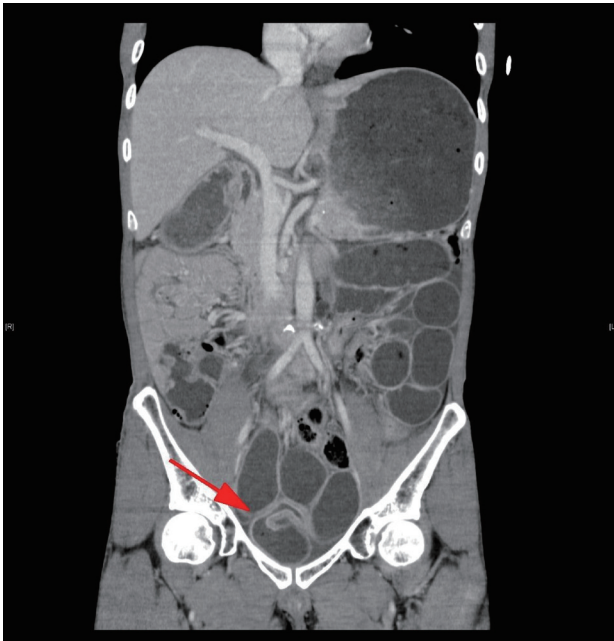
Computed tomography findings at the time of consultation. Computed tomography showed bowel dilatation and caliber changes in the pelvic floor (red arrow), with no closed loop.
